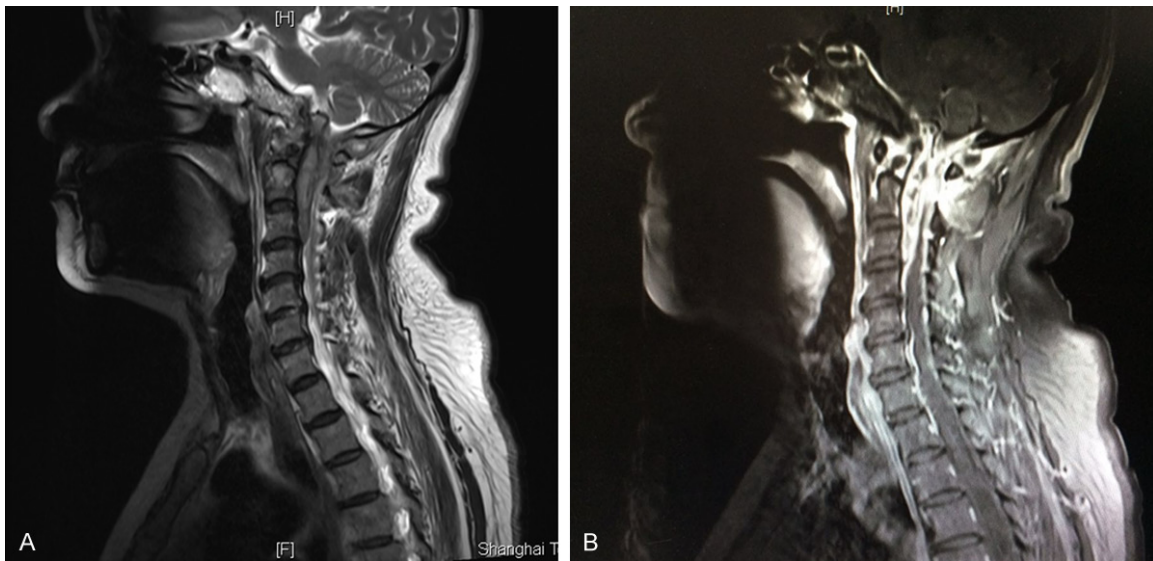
Reexamined magnetic resonance imaging demonstrated C1-3 suspected multiple abscess as well as extended inflammation of upper cervical and intracranial meninges. A: Normal; B: Enhanced.
